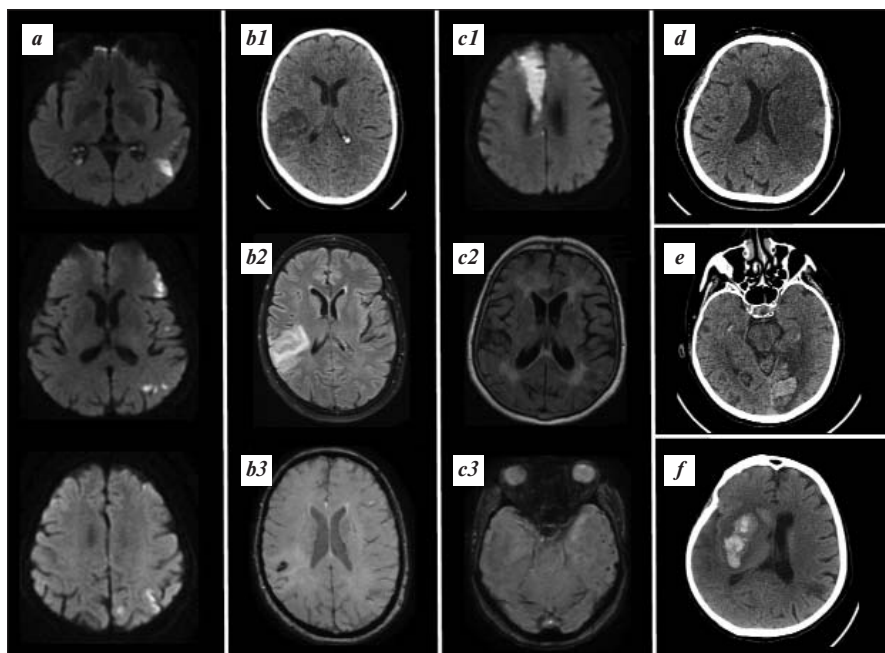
Determination of the time of the OACs initiation in different clinical situations. *a* – 72-year-old female, NIHSS upon admission – 6 points. Maximum infarct size – 2 cm (MRI, DWI), without hemorrhagic transformation. DOACs initiated on the 3rd day; *b* – 66-year-old female, NIHSS upon admission – 3 points. Maximum infarct size – 4 cm (b1 – CT, b2 – MRI FLAIR). Hemorrhagic infarction type 1 on CT (b1) and MRI SWAN (b3) scans. DOACs initiated on the 10th day; *c* – 76-year-old female, NIHSS upon admission – 3 points. Maximum infarct size – 8 cm (c1 – MRI DWI). No signs of hemorrhagic transformation, but lobar cerebral microbleeds on MRI SWAN scans (c3) and severe (Fazekas 3) white matter hyperintensities on MRI FLAIR (c2) are present. DOACs initiated on the 10th day; *d* – 68-year-old female, NIHSS upon admission – 15 points. Maximum infarct size on CT scan – 12 cm, without hemorrhagic transformation. DOACs initiated on the 10th day; *e* – 80-year-old female, hemianopia upon admission to the ASU (NIHSS – 1 point). Absence of infarct on CT scan, therefore DOACs were started on the 3rd day according to Diener's rule. CT control after 1 week revealed a hemorrhagic transformation into hemorrhagic infarction type 2, which was regarded as asymptomatic. DOACs were not discontinued; *f* – 80-year-old female, NIHSS upon admission – 14 points. Intravenous thrombolysis was administered. CT-control revealed a type 2 intraparenchymal hematoma. DOACs initiation was recommended in the outpatient setting on the 40th day
